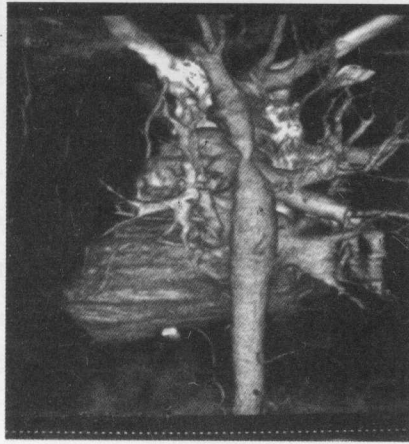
CT angiography showing coarctation of descending aorta in an 18-year-old male patient.
